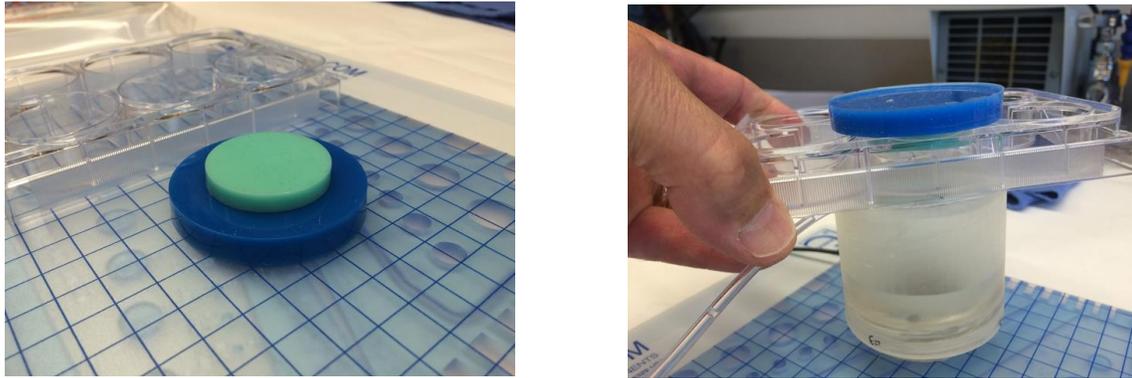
Exploratory development of cell culture system designed for studying LIPUS with cultured human disc cells. (a) a multilayer acoustic absorber that can be sterilized and placed above the cell media will be used to ensure negligible standing waves and heating during LIPUS; (b) the cell culture plates can be placed on our ultrasound applicator within an incubator as shown. This represents ancillary studies to gather preliminary data to help support NIH funding.
